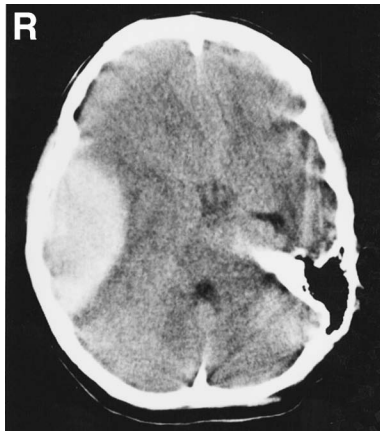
Computed tomography scan on admission showing an epidural hematoma in the right middle fossa, with marked midline shift.
